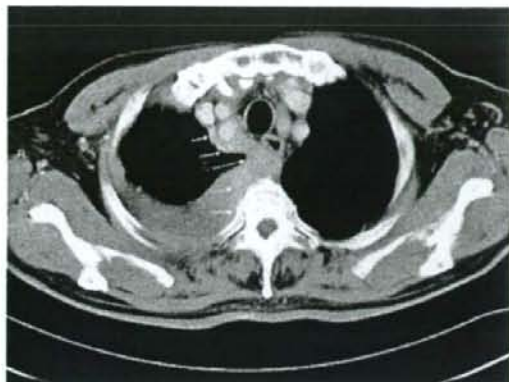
Chest CT scan showing diffuse prominent thickening of right mediastinal pleura (arrows) and pleural effusion.
